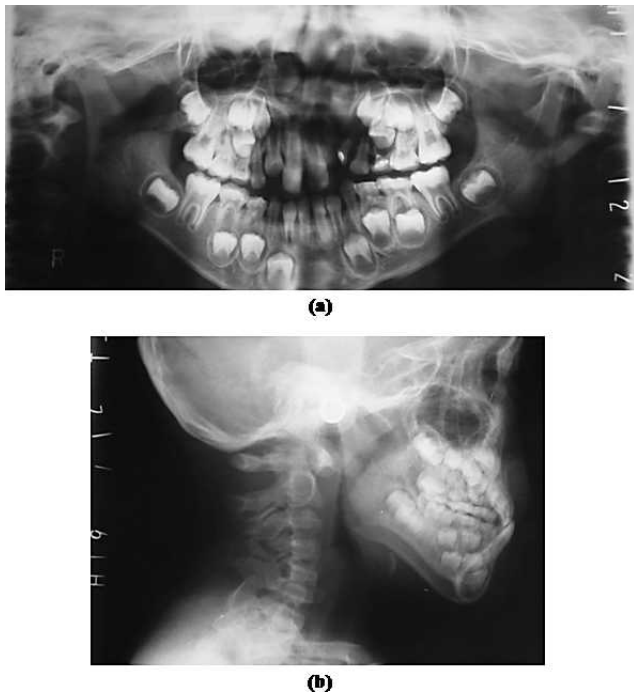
(a) Panoramic radiograph of the patient. (b) Lateral cephalogram of the patient.
